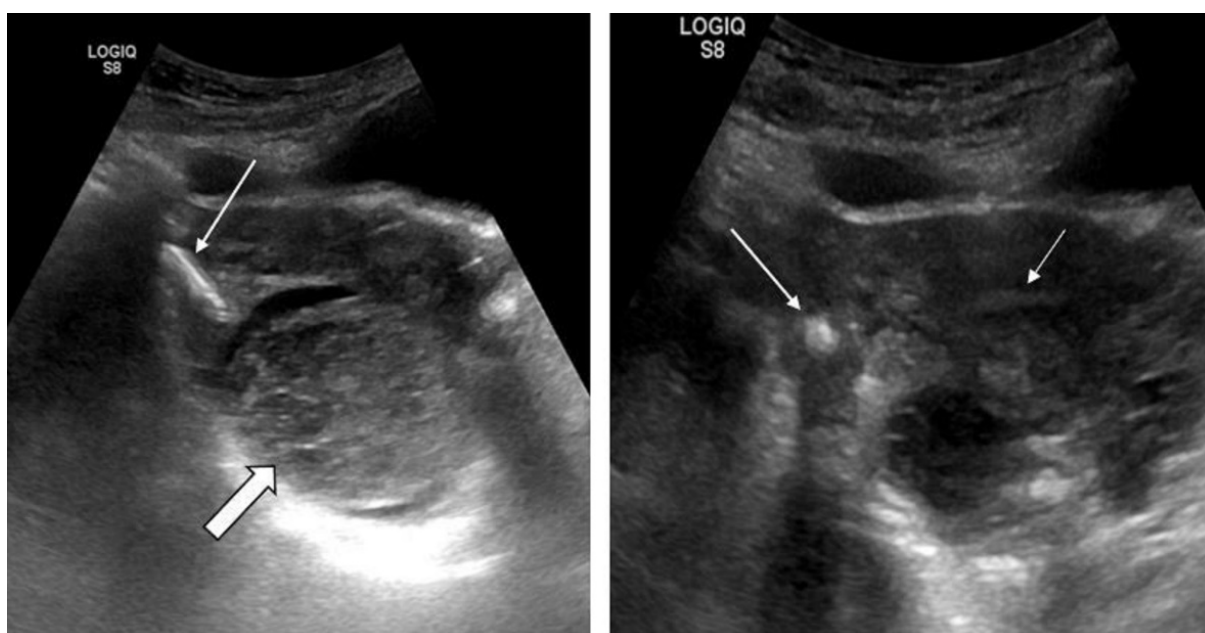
Transabdominal ultrasound showing empty uterine cavity (short arrow) associated with migrated IUD adjacent to the uterus (long arrows), also a complex cystic lesion near the dislocated IUD (thick arrow)
